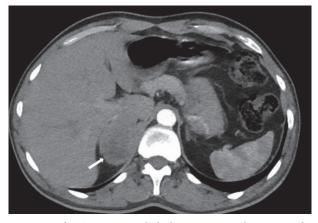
Axial CT image revealed a heterogeneous lesion in right adrenal gland (arrow).
